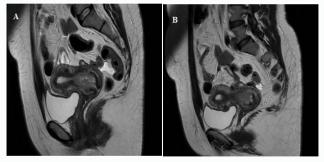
A and B). Sagittal sections of MRI, seq.T2. The hypointense uterine lesion invaded the surrounding myometrium for less than 50% of its thickness. (Fondazione IRCCS Policlinico Universitario A. Gemelli, Rome).
